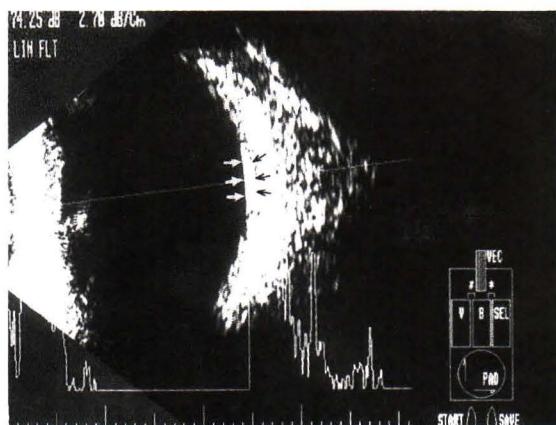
Patient 1. Ultrasonography of the left eye A) high reflectivity echogenic mass (arrows). Note the flat-top bone density of the lesion and a plano-convex configuration. B) high reflectivity persisted even at reduced system sensitivity.
